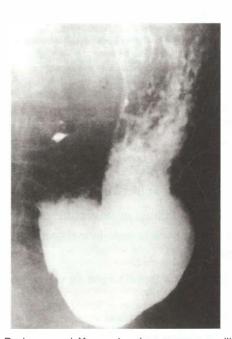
Barium meal X-ray showing enormous dilatation of the stomach and failure of barium to fill into the distal intestine
